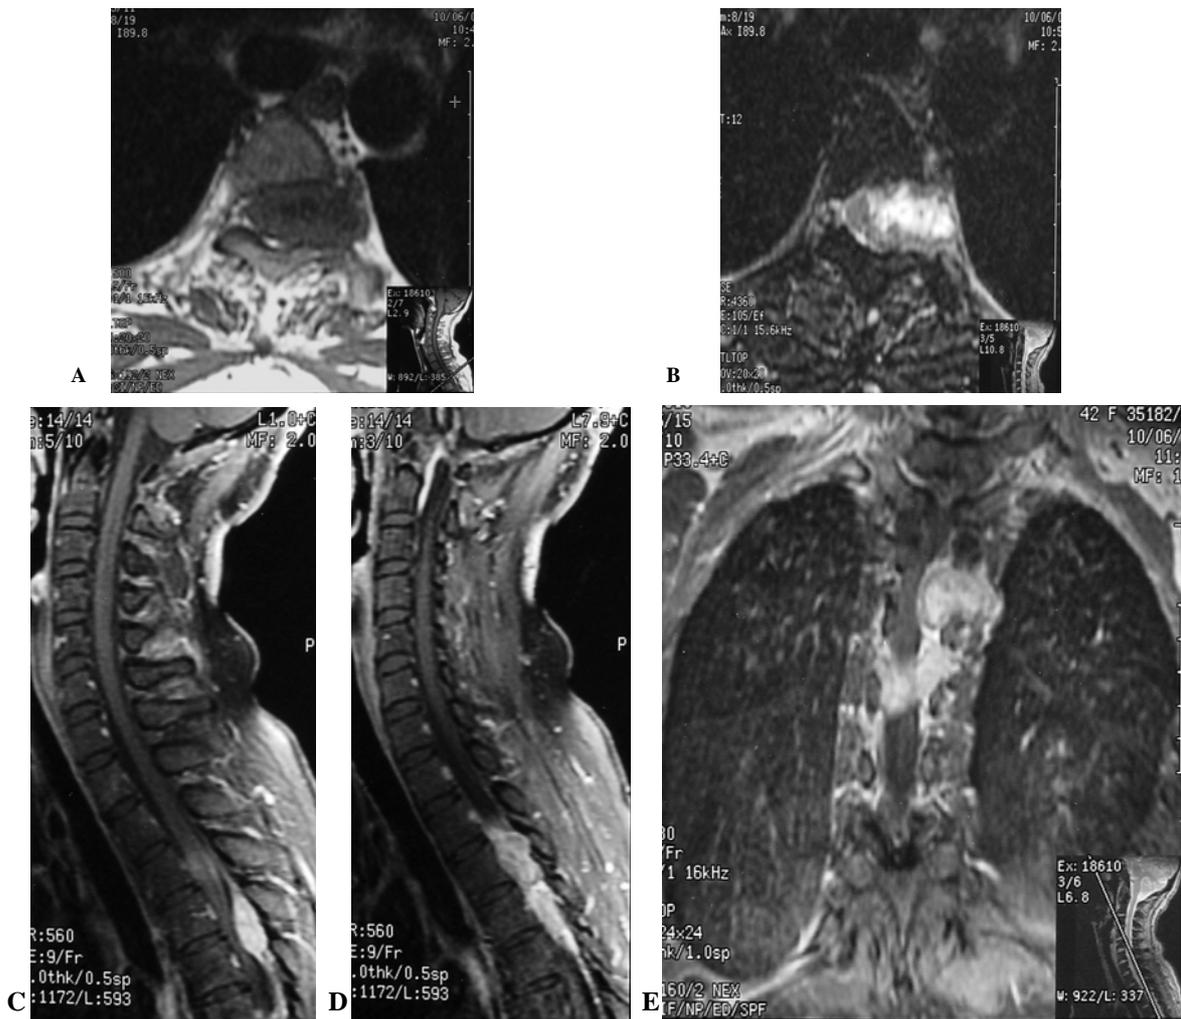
Case II : A 43-year-old female presented with back pain and cervical myelopathy. Axial MR image reveals lobulated mass in the widening left neural foramen with intraspinal extension. This lesion shows mixed isosignal intensity at the peripheral portion and low signal intensity in the central portion on T1-weighted image (A) and turn to bright signal intensity on T2-weighted (B). Post contrast sagittal (C,D) and coronal (E) T1-weighted images with fat suppression demonstrates multilevel involvement at T3-T6 on the left side and T6-T7 on the right side
